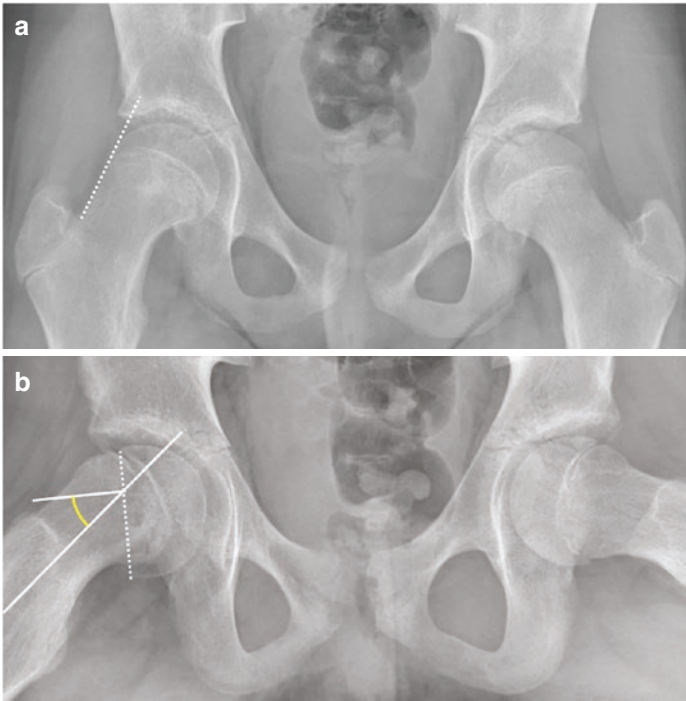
(a) Anteroposterior radiographs showing the Klein line and (b) Southwick SCFE measurement in the frog-leg lateral view
